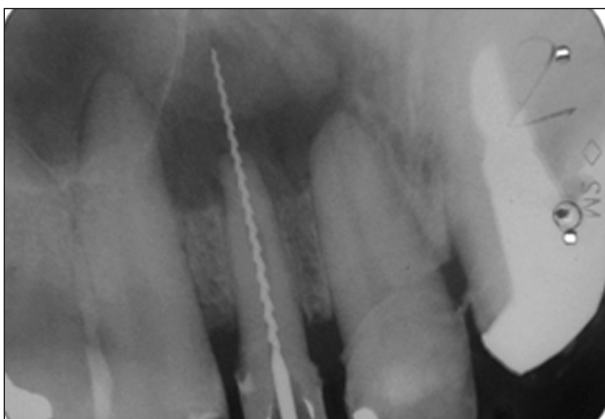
Radiograph bought by the patient, which shows a large radiolucent lesion involving the root apex of 12 and extending to the periodontal areas of 11 and 12.
